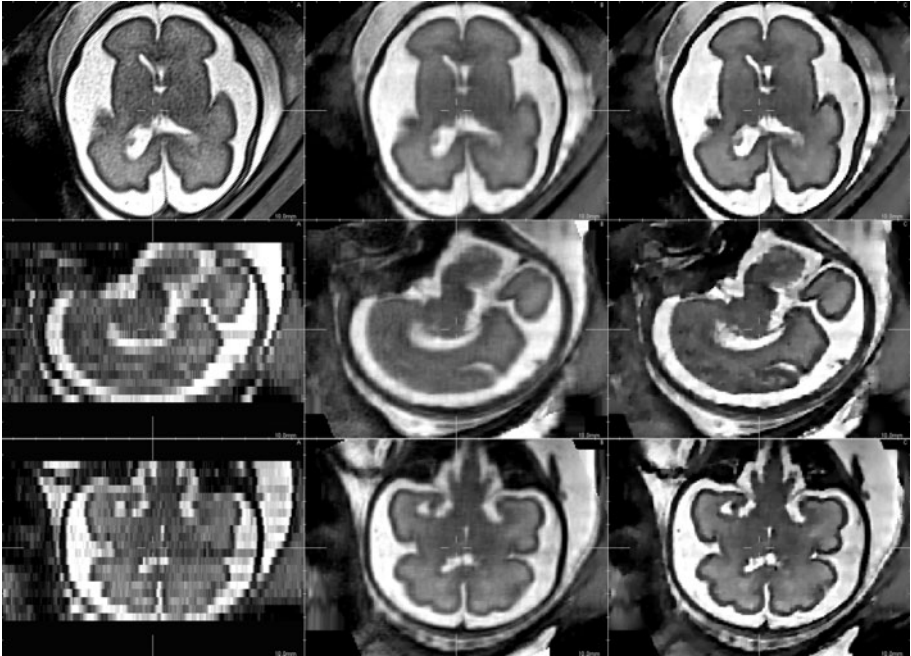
Details of a reconstructed fetal brain MR image using 3 orthogonal LR images. From left to right: A) original low resolution image, B) reconstructed image using local sparse interpolation [4], C) SR reconstruction using J_{Ch} regularisation.
